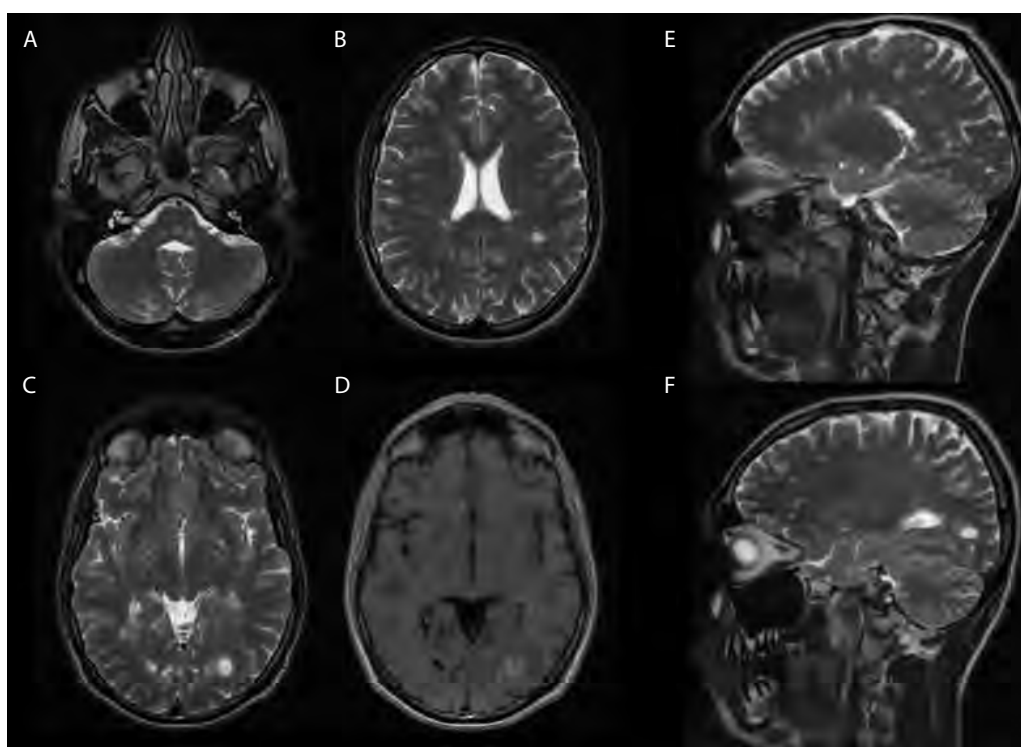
A, B. MRI scans of the brain in T2-weighted FLAIR sequence, axial plane, at four weeks. MS lesions in the brain (hyperintense areas). C, D. MRI scans of the brain in T1-weighted contrast-enhanced sequence, axial plane. E, F. MRI scans of the brain in T2-weighted sequence, sagittal plane – lesions arranged radially to the corpus callosum
